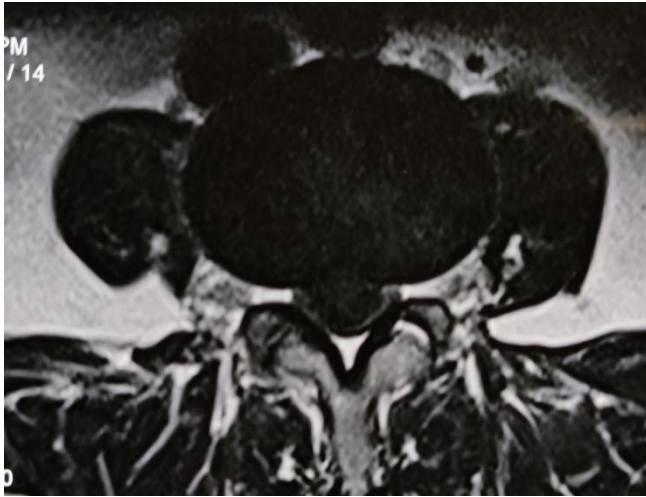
MRI Lumbo sacral spine (T2) Axial section showing prolapsed L3L4 di
